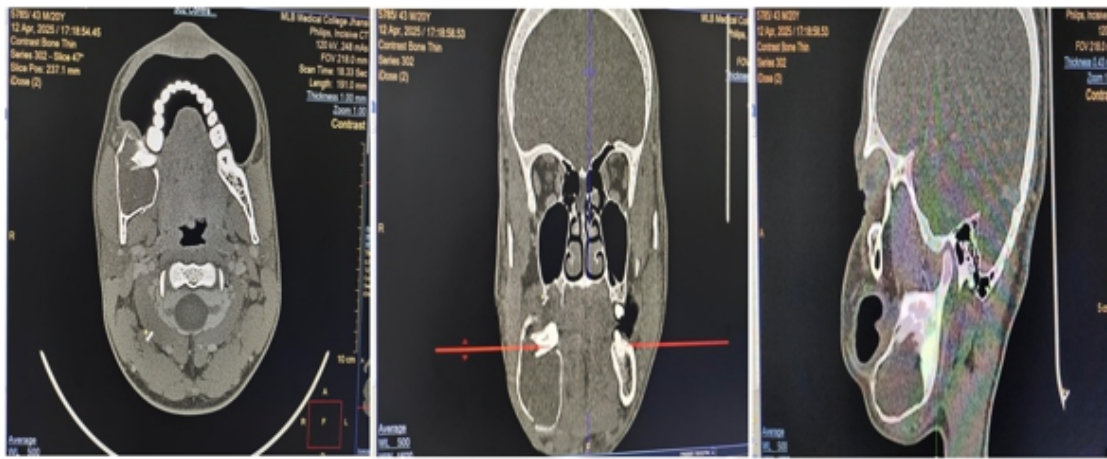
CT Imaging Showing Odontogenic Keratocyst of Right Mandible (Axial, Coronal, and Sagittal Views)
